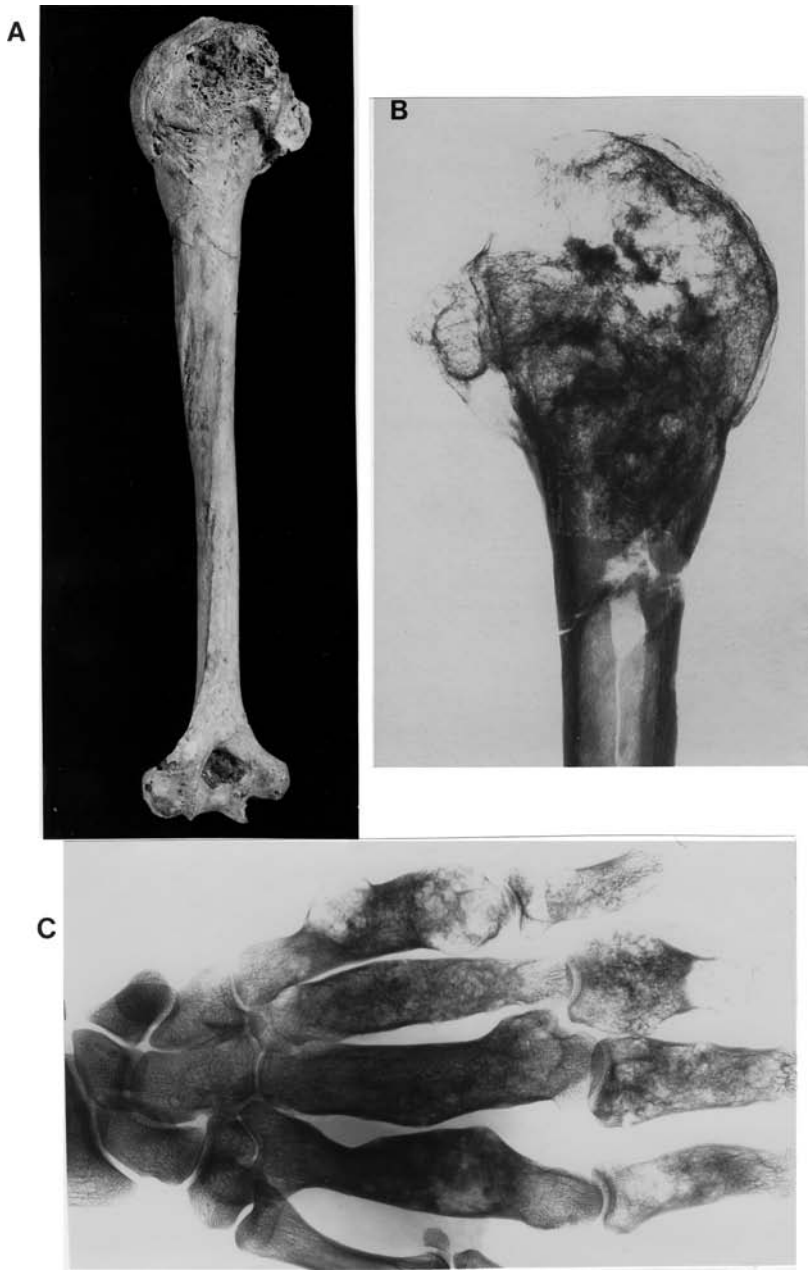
(a) Early Nubian humerus with swollen proximal end. (b) The same humerus X-rayed, and suggesting a fibrous dysplasia or possibly an osteoclastoma. (c) Recent case of enchondromatosis, with multiple cartilage tumours affecting a number of metacarpals and phalanges
